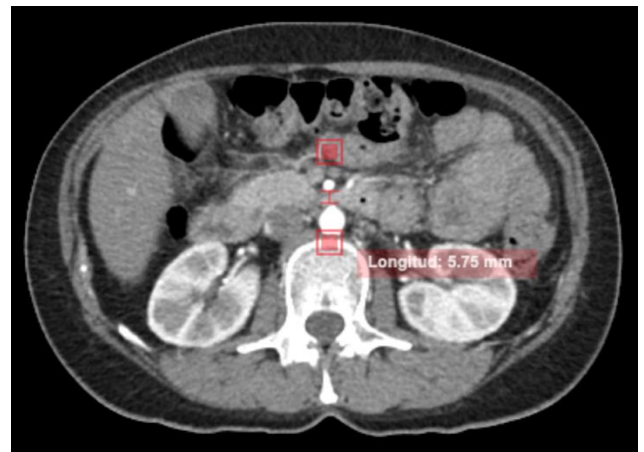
Abdominal computed tomography in axial projection with contrast in the arterial phase, a compression of the third portion of the duodenum and distance between the aorta and SMA less than 8mm is observed.
